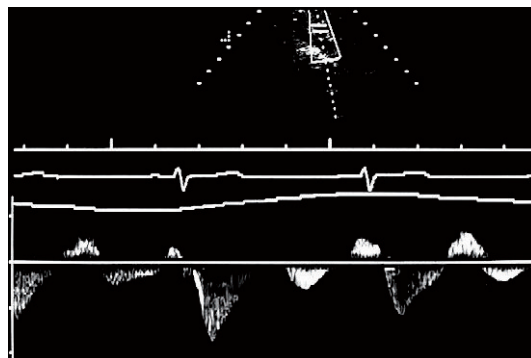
Spectral Doppler tracing in a patient with severe alcohol-induced cirrhosis. Portal vein velocity has decreased although flow does remain hepatopetal through most of the cardiac cycle. Note the marked periodicity, however, which coincided with hepatic arterial systole.
